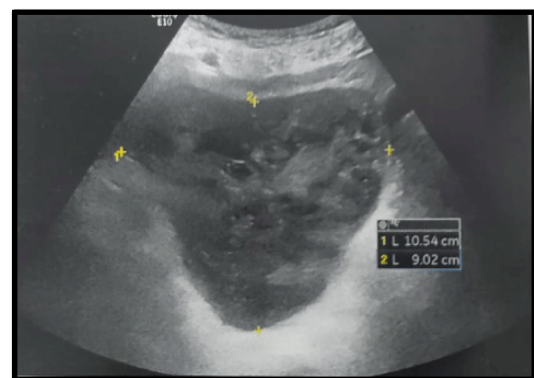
Ultrasonography revealing a pelvic mass
